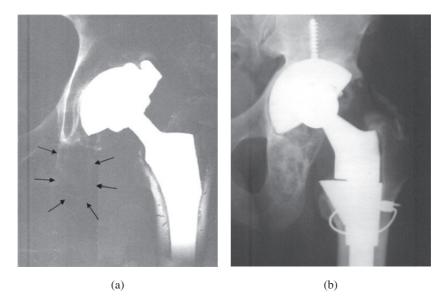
Bioactive glass grafting of a unicameral cyst in the ischium. (a) Preoperative radiograph. The arrows indicate the site of cyst. (b) Three years post-implantation and revision arthroplasty, site has healed with no cyst recurrence.
